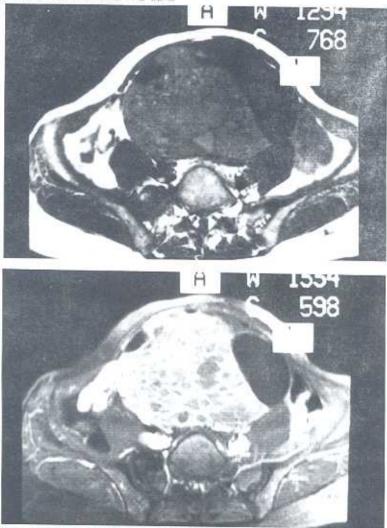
Mucinous cystadenocarcinoma, a) T1-W axial image shows multiseptated complex cystic mass and hyperintense content which is consistent with mucine, b) Contrast-enhanced fat-saturated MR image clearly delineated multiple, thick, contrast-enhanced septations.
